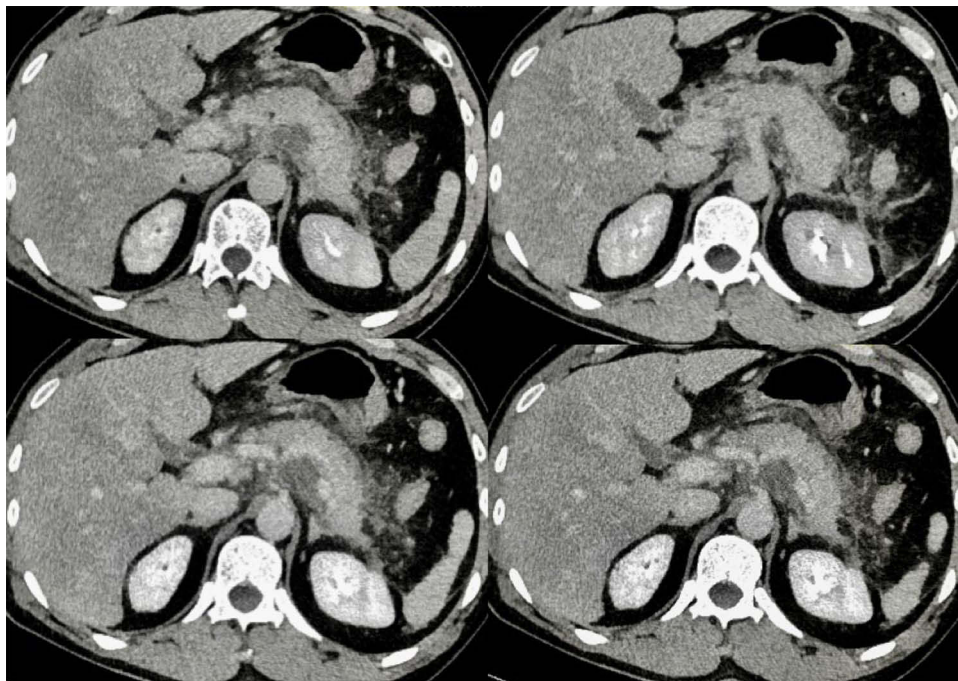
Abdominal computed tomography in a 44-year-old woman showing interstitial edema of the pancreas with the homogeneous enhancement of the pancreatic suggesting benign edematous pancreatitis with no evidence of gallstones.
